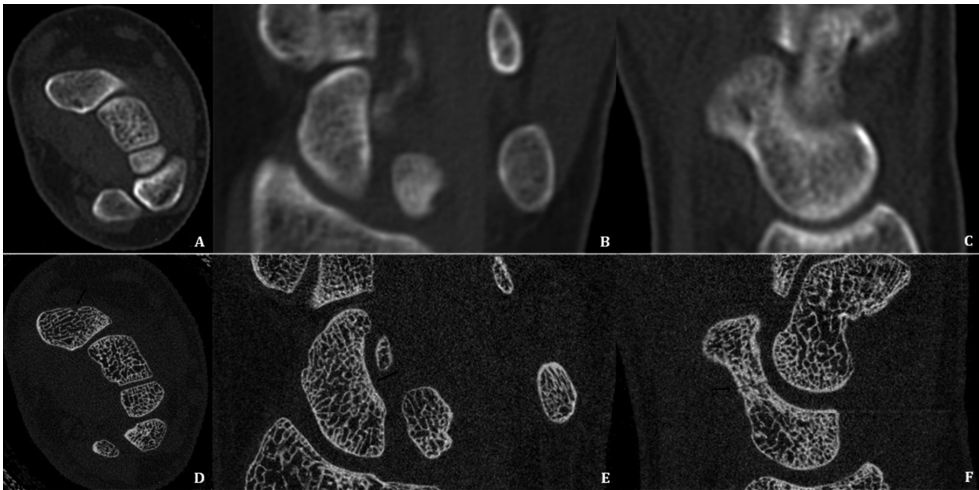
A 38-year-old woman with a type-A2 scaphoid fracture that was diagnosed on HR-pQCT scans. A-C) Transverse (A), coronal (B), and sagittal (C) CT slices that were negative for scaphoid fracture. D-F) Transverse (D), coronal (E), and sagittal (F) HR-pQCT scans that were positive for scaphoid fracture (arrows).
